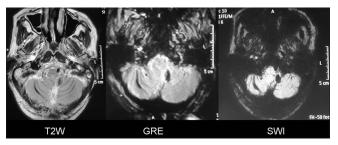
T2-weighted, gradient echo, and susceptibility echo (susceptibility-weighted imaging) sequences showing deposition of hemosiderin in the crests of bilateral cerebellar folia, vermis, and brainstem
